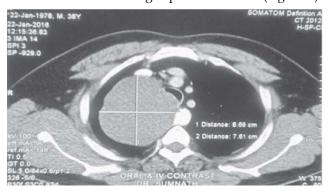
contrast-enhanced computed tomography of chest showing right-sided well-defined homogeneous encapsulated mediastinal mass, measuring 8.69cm × 7.61cm, medially compressing the trachea.
